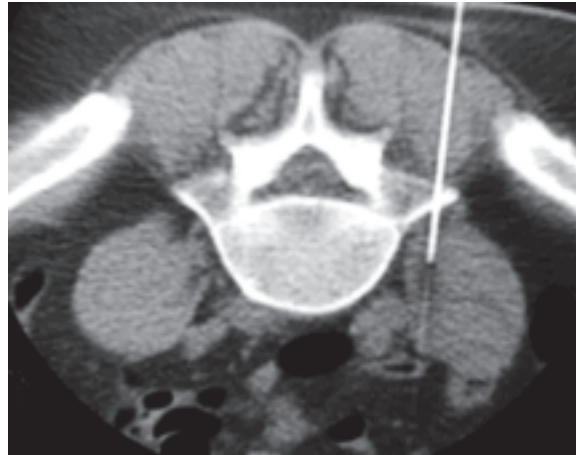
CT-guided aspiration of a small right psoas abscess in a 45-year-old man. Aspiration was performed with the patient lying prone. The psoas abscess was detected on MR scans (not shown).
